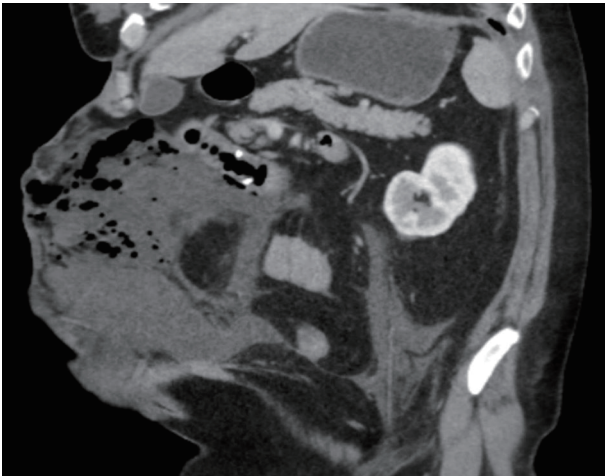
Computed tomography (CT) of abdomen and pelvis with intravenous contrast showing the site of perforation in the duodenum.
